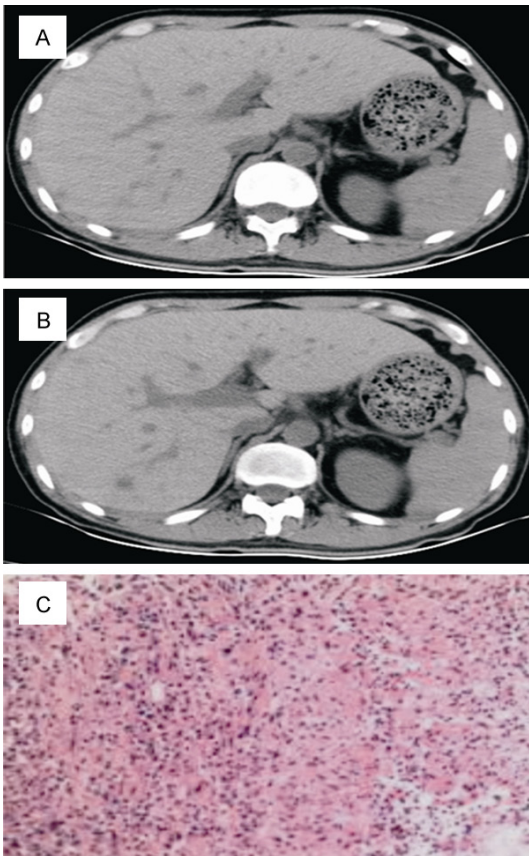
Presentation of Case 4. A, B. CT scan demonstrated hypodense lesions in the liver and spleen. C. Ultrasound-guided fine needle aspiration biopsy showed inflammation changes of the liver tissues, which were likely granulomatous inflammation.
